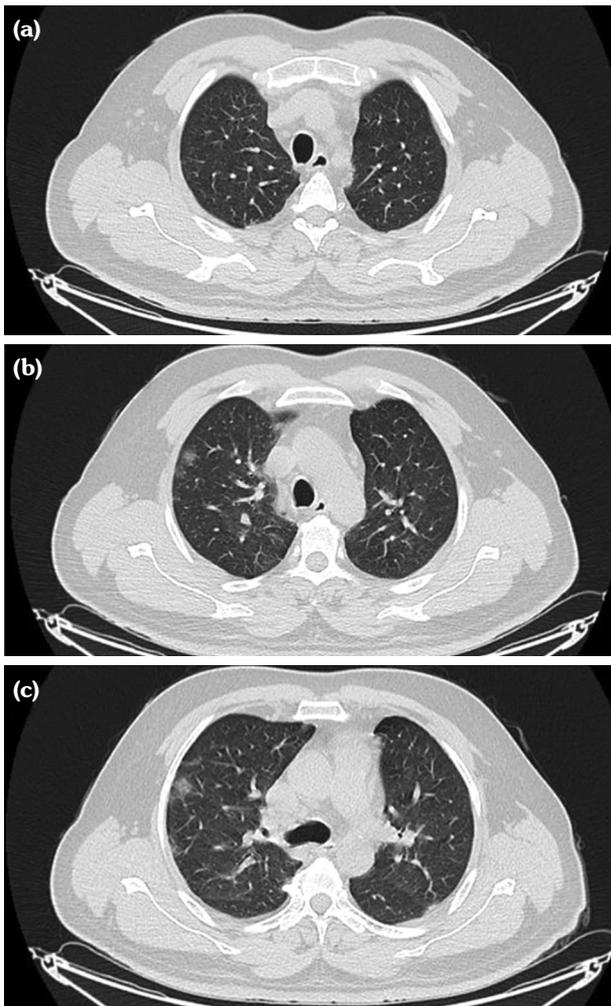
Initial CT images obtained on August 01, 2020. (a) A CT image showing upper lobes of lungs. (b) Ground-glass opacities in right upper lobe. (c) Peripherally located ground-glass opacities in right upper lobe.
